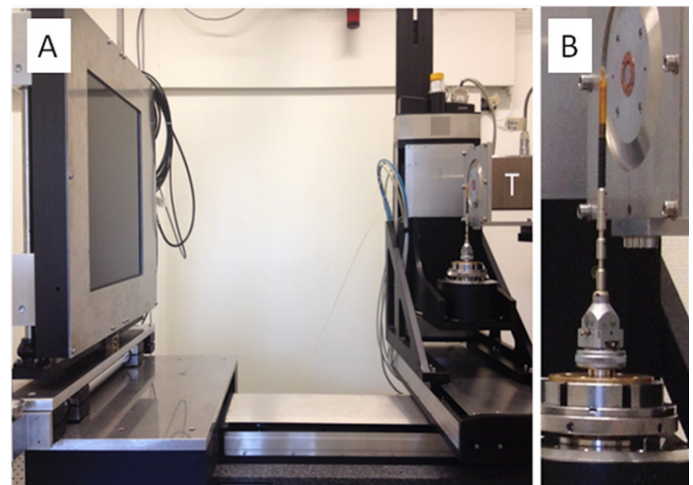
X-ray microtomography set-up with the X-ray tube T (A) and close-up of the Kapton tube holding sample (B).
